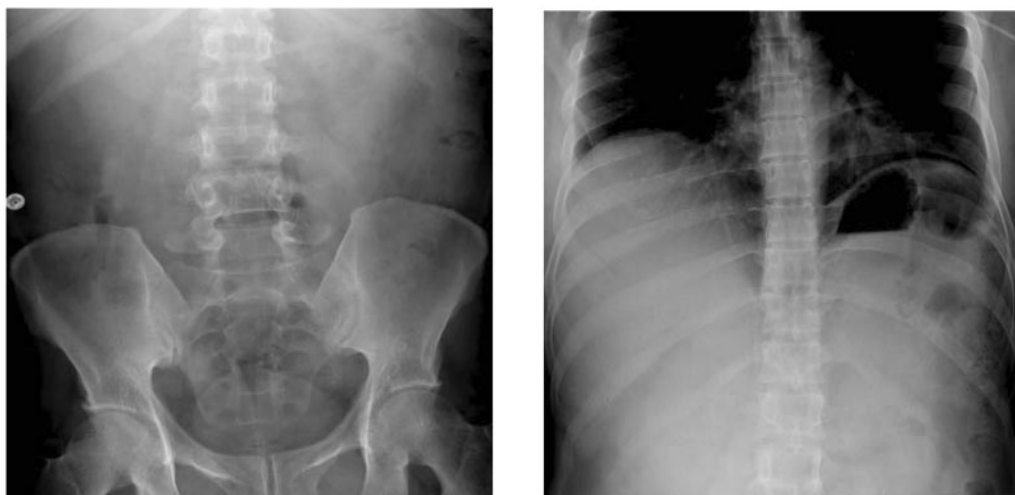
Plain radiograph of lower chest and abdomen.
